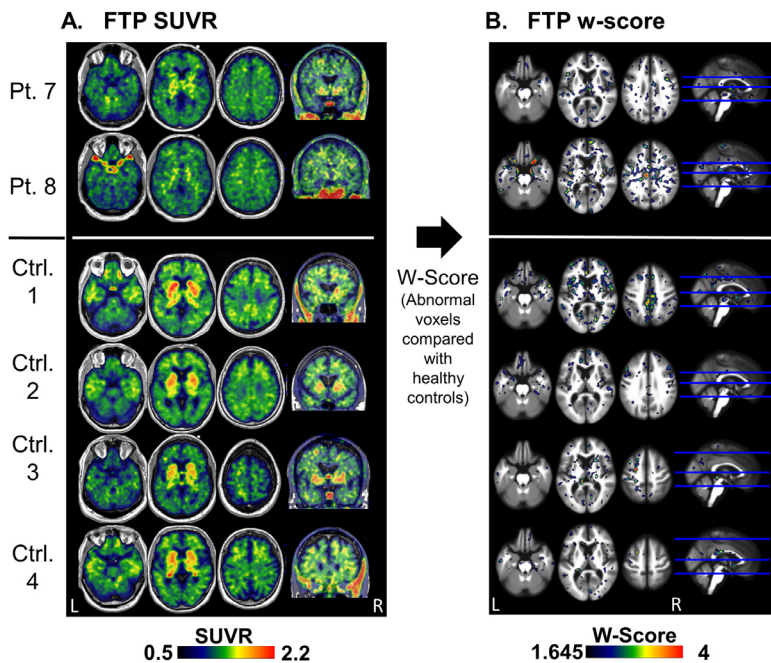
Tau (FTP) PET “dot-like” pattern in TES patients and in CN FTP SUVR (A) and w-score (B) images of two patients (patients 7 and 8) and four control subjects that have a non-specific distribution of small clusters with mildly elevated binding. Abbreviations: FTP = flortaucipir; TES = traumatic encephalopathy syndrome; CN – cognitively normal control; Pt. – patient; Ctrl. – control; SUVR - standardized uptake value ratio; W-score = age adjusted z-score.
